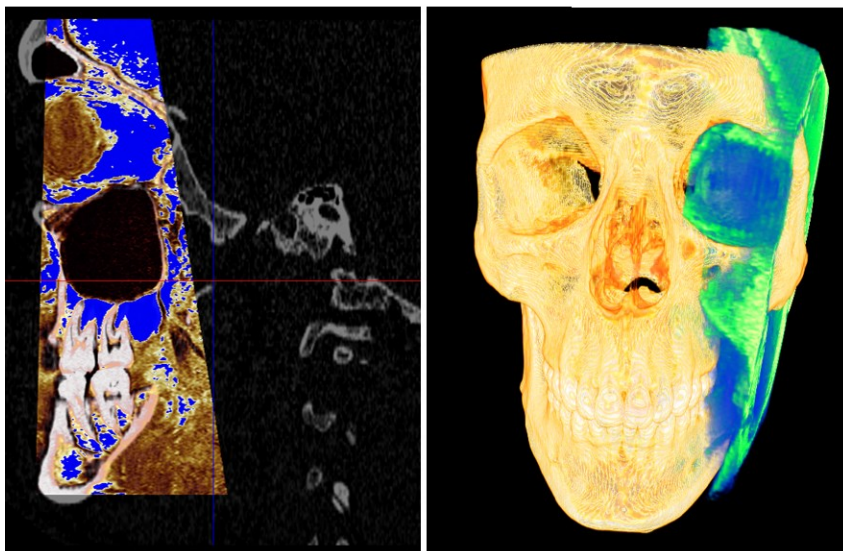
Registered CT and MRI data for closed mouth position (left: overlaid sagittal slices; right: renderings of CT (yellow) and MRI (green/blue) data)
